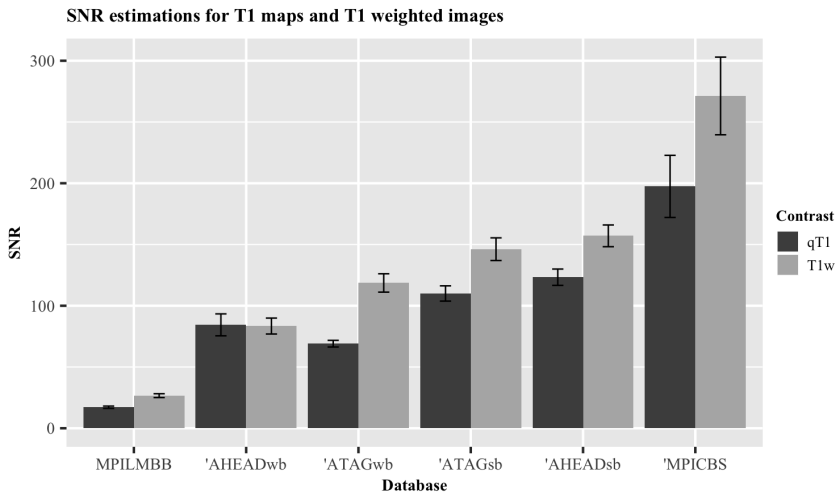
Graphical representation of difference in normalized SNR_{CC} values for quantitative T1 maps and T1-weighted images. Databases marked with an apostrophe (') indicate 7T data. qT1, quantitative T1 map; T1w, T1-weighted; wb, whole-brain; sb, slab. Error bars indicate standard error of the mean.
